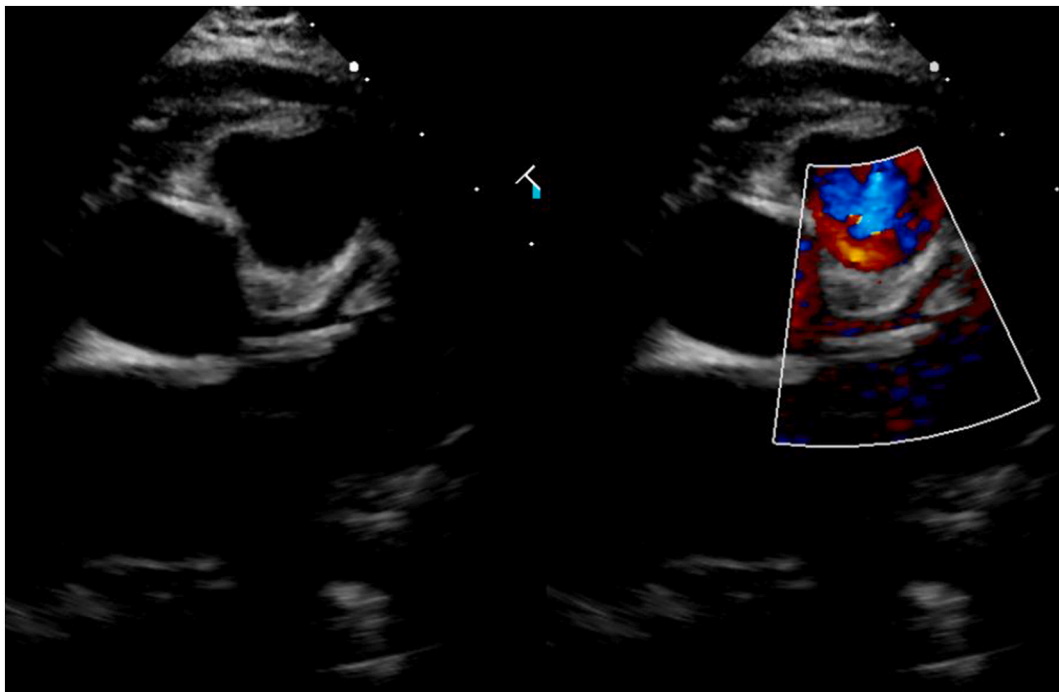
Normal origin of the left coronary artery. In this picture the left coronary artery can be seen arising from the left sinus of Valsalva, at approximately the 4 o'clock position. Color Doppler imaging shows a red Doppler color pattern, indicating appropriate flow from the aorta into the left main coronary artery. The left main coronary artery can also be seen bifurcating into the left anterior descending and the circumflex coronary arteries. Flow within the normal left anterior descending branch should appear red as it courses upwards towards the transducer in this image. Flow within the normal left circumflex branch may appear red or blue depending on its course and the angle of imaging.
